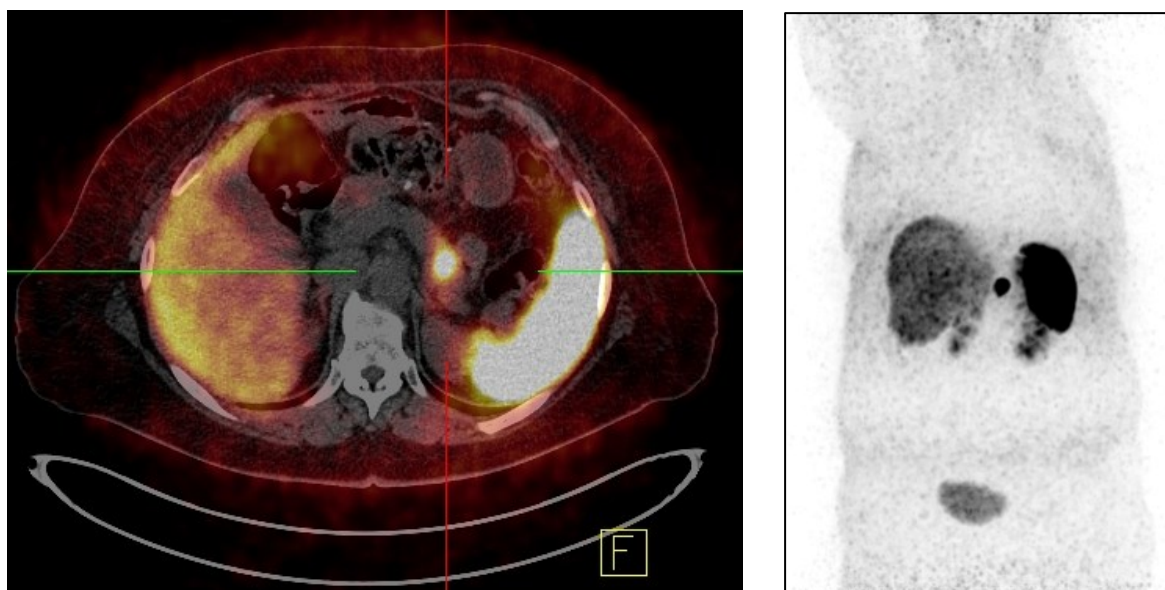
Primary identified in the pancreatic cauda with SUV_{max} 44.00 and volume of 31.49 cm^3
